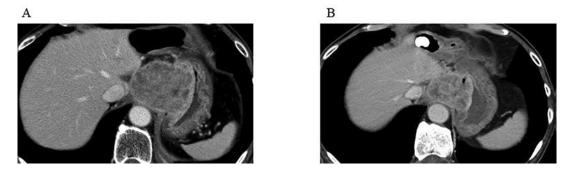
Baseline computed tomography (CT) (A) and first follow-up CT (B) in case 4.
